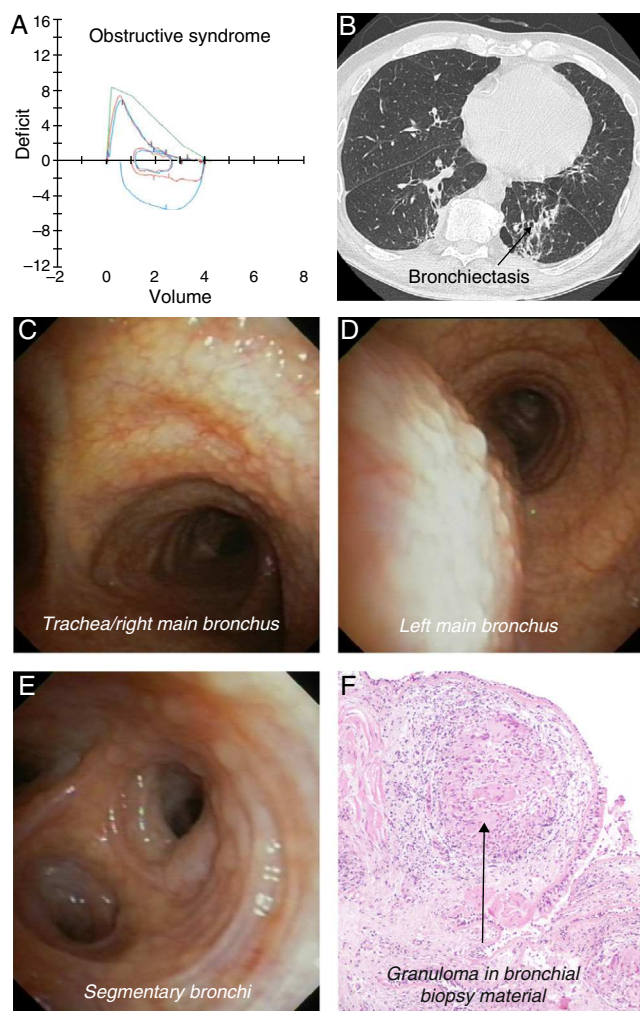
(A) Lung function tests showing mild obstruction. (B) Chest computed tomography showing mainly bronchiectasis in the left lower lobe. (C)–(E) Bronchoscopy showing miniscule disseminated lesions, spreading from the upper trachea to the segmentary and sub-segmentary bronchi on both sides, with circular distribution in all membranous and cartilaginous parts of the airways. (F) Non-caseating epithelioid cell granulomas.
